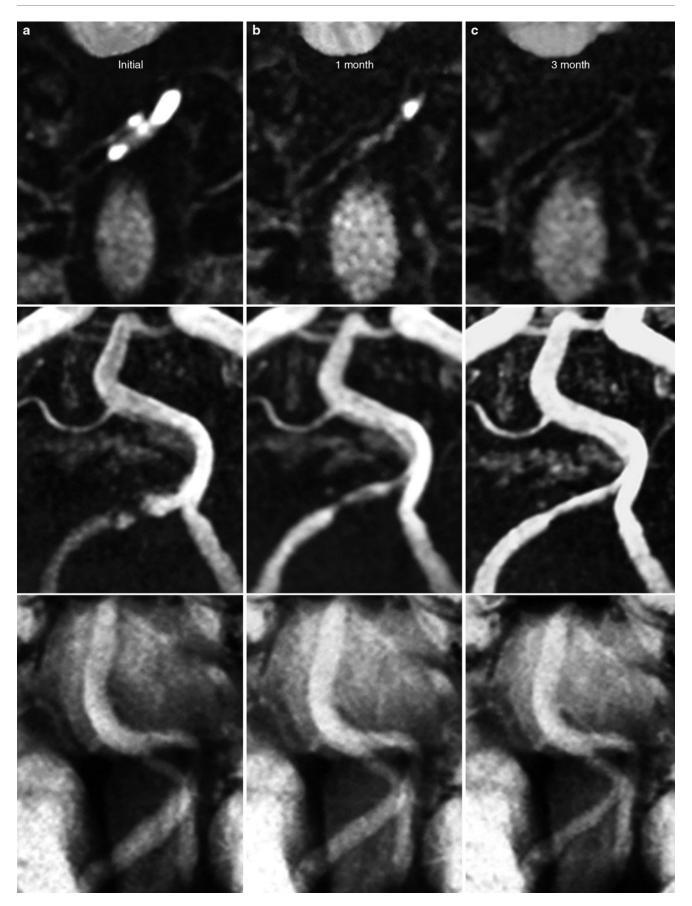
Initial MRI was performed 2 days after the onset (a), follow-up MRI 1 month later (b), 3 months later (c). VISTA and MRA revealed a normalized artery. On VISTA, the intramural hematoma had regressed.
